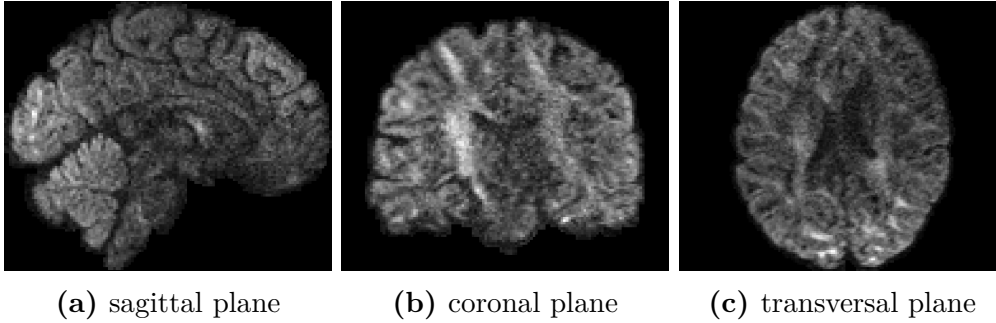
Diffusion MRI acquisition of the HCP data set (for one single gradient direction; see Sec. 3.3).
